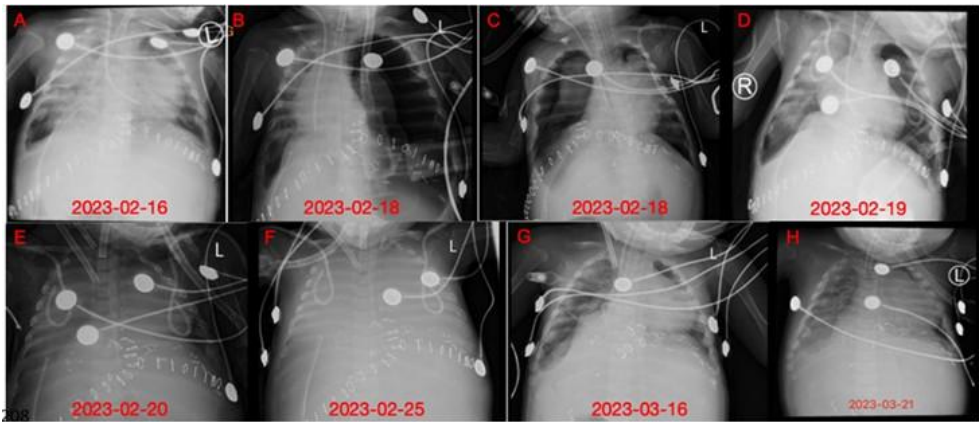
Changes in chest X-ray during the patient's course of illness. A: Bilateral diffuse infiltrates (POD 2). B: Left-sided pneumothorax (POD 4). C: Right-sided pneumothorax after closed drainage (POD 4). D: Left-sided pneumothorax persists after bilateral closed drainage (POD 5). E: Bilateral diffuse infiltrates, day 1 of ECMO treatment (POD 7). F: Bilateral diffuse infiltrates, day 6 of ECMO treatment (POD 11). G: Bilateral diffuse infiltrates, significant improvement compared to previous days. Day 25 of ECMO treatment (POD 30). H: Bilateral diffuse infiltrates, ECMO weaning (POD 35).
